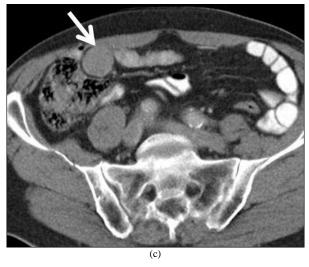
Contrast-enhanced computed tomography depicting mesenteric and retroperitoneal masses.
